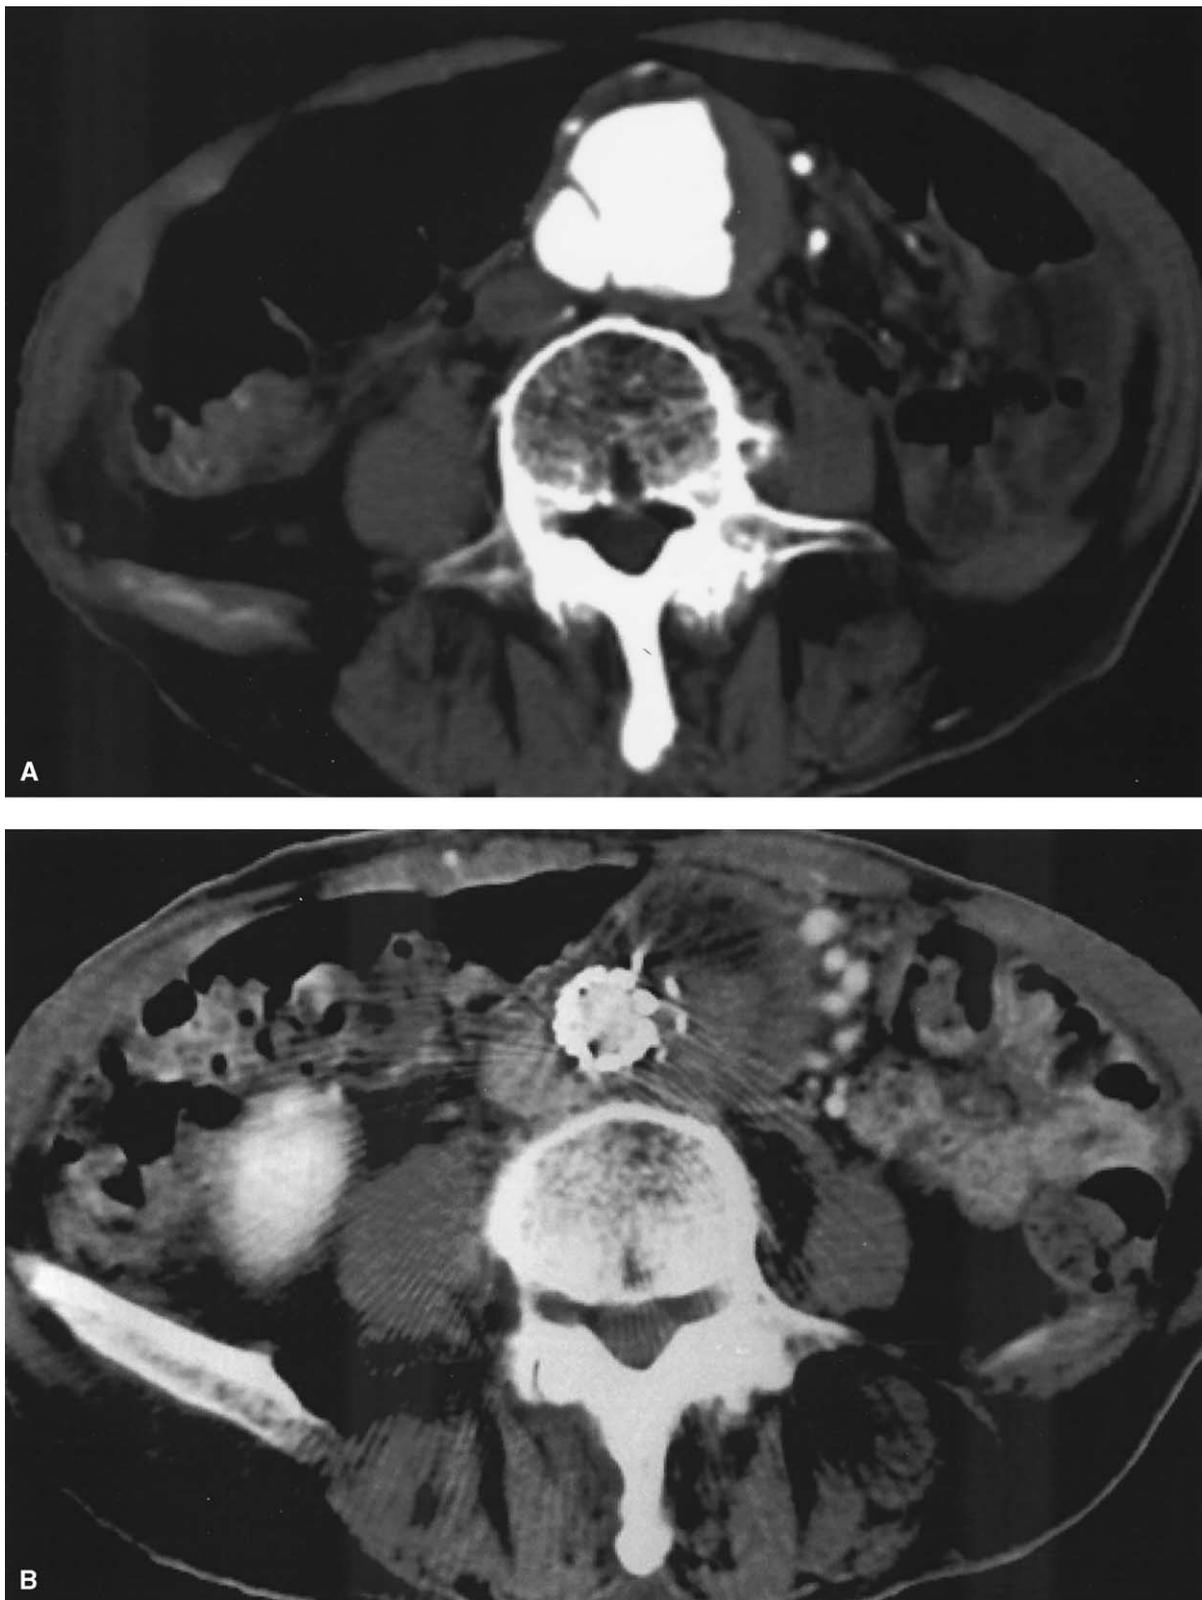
Patient 2. Penetrating atherosclerotic ulceration in the abdominal aorta with pseudoaneurysm. A, Preoperative contrast-enhanced CT scan. B, Contrast-enhanced CT scan obtained 8 days after endovascular stent grafting demonstrates complete exclusion of the lesion and the adventitial pseudoaneurysm.
